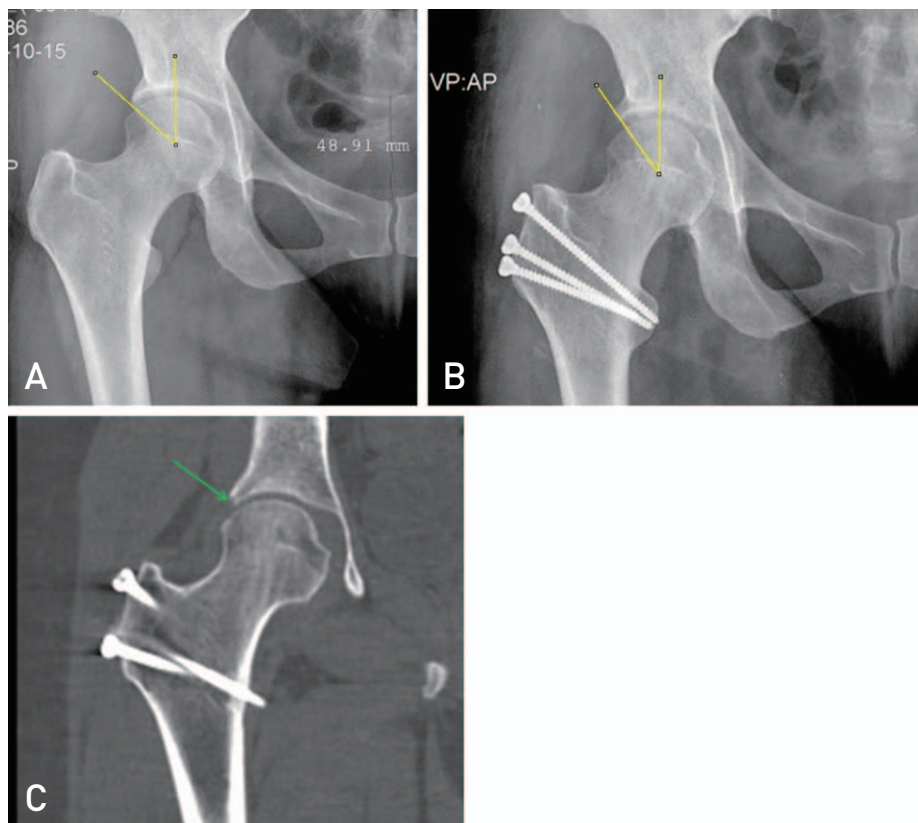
Change of lateral center-edge angle. (A) 50° before acetabular osteochondroplasty; (B) 36° after acetabular osteochondroplasty. (C) The arrow indicates area of trimmed acetabular rim on computed tomogram.
